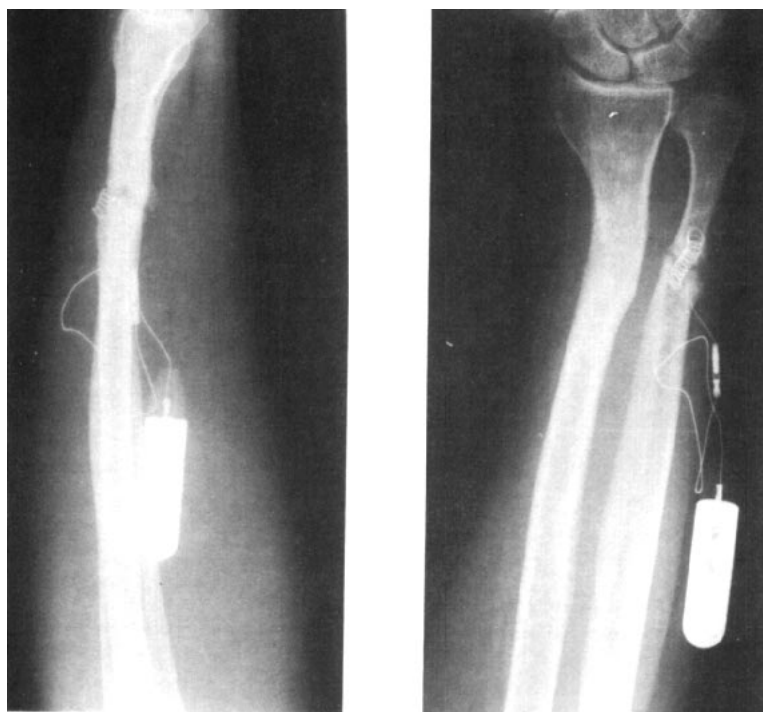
Two x-ray views of an implanted direct current device for stimulation of healing in a fractured ulna which had a nonunion for 1½ months.
